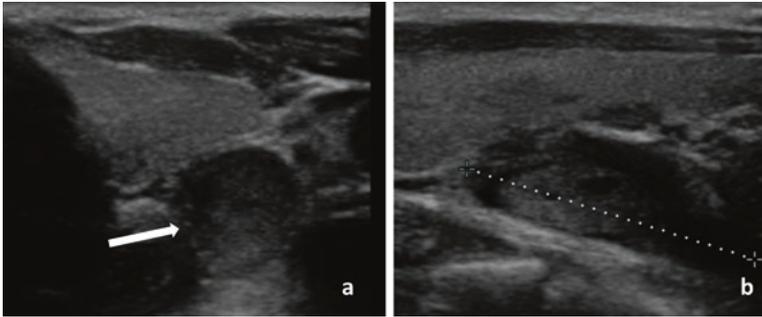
Transverse (a) and longitudinal (b) ultrasound images showing a left inferior parathyroid adenoma. Parathyroid adenomas are generally rounded or ovoid on transverse view (a, arrow) and ovoid with a polar vascular supply on longitudinal imaging (b, dotted line). This distinguishes them from lymph nodes, which are more rounded and have a central hilar vascular supply
